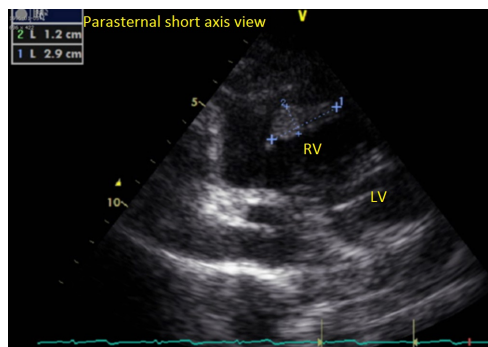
Echocardiography, two chamber view, thrombus in RV.
